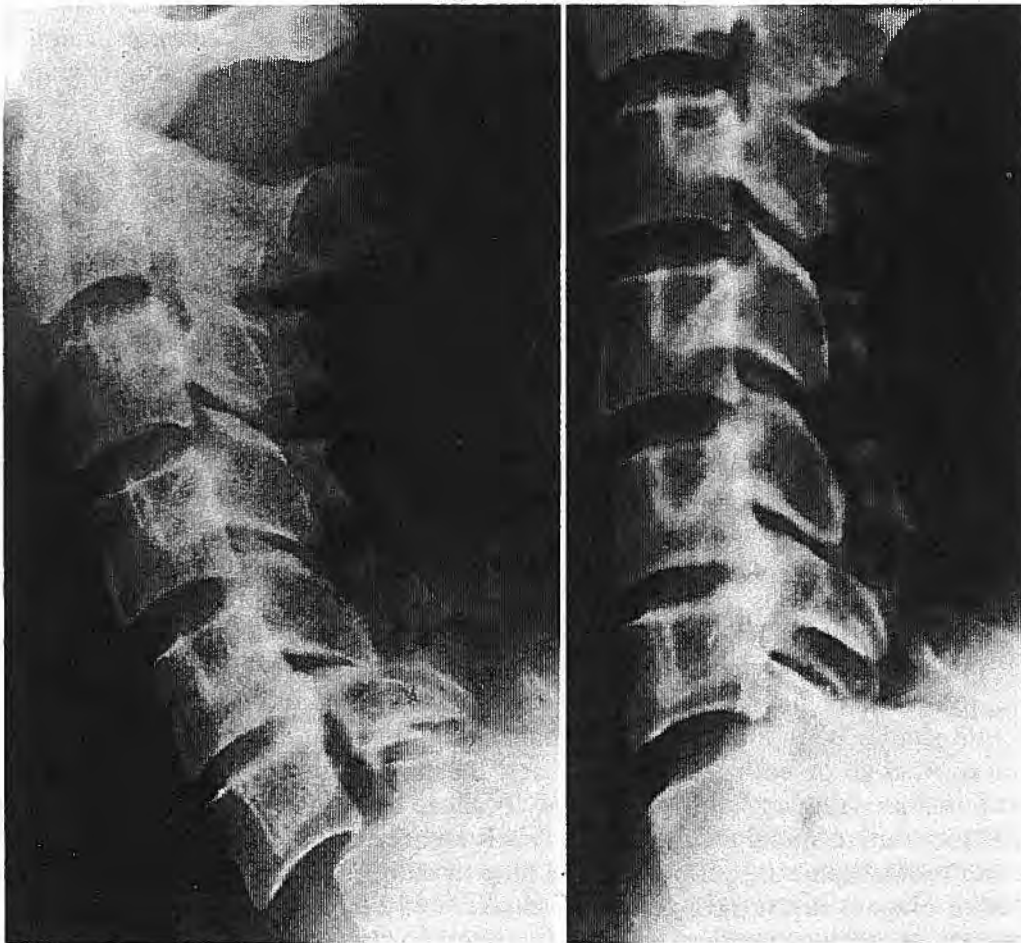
Fracture-dislocation of C6 on C7. Poor radiography failed to demonstrate the fracture-dislocation in the film on the right
